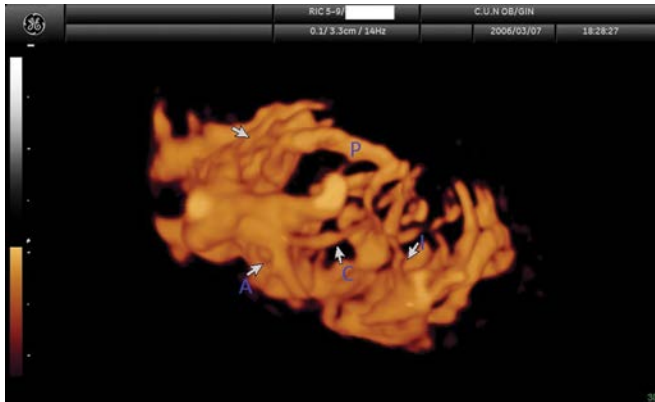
Three-dimensional ultrasound depicting a 3D reconstruction of the vascular tree of an ovarian tumor. Some suspicious features, such as irregular branching (I), vessel caliber change (C), shunt connections (A), and pseudoaneurysms (P) can be observed.
